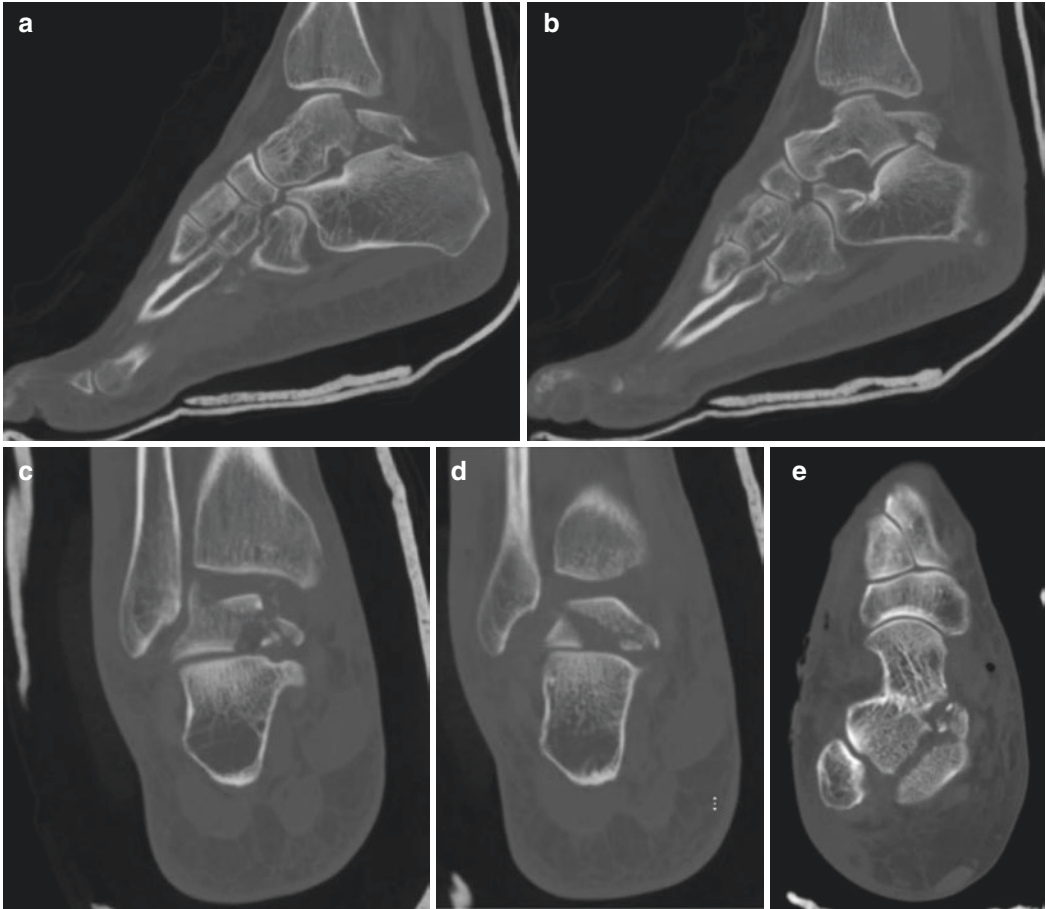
Preoperative CT cuts for Case 1. “Shown are select computed tomography cuts after closed reduction. (a, b) show select sagittal cuts demonstrating coronal shear of the body. (c, d) exhibit coronals demonstrating comminution. Axial cut (e) shows the oblique fracture line entering the subtalar joint”
